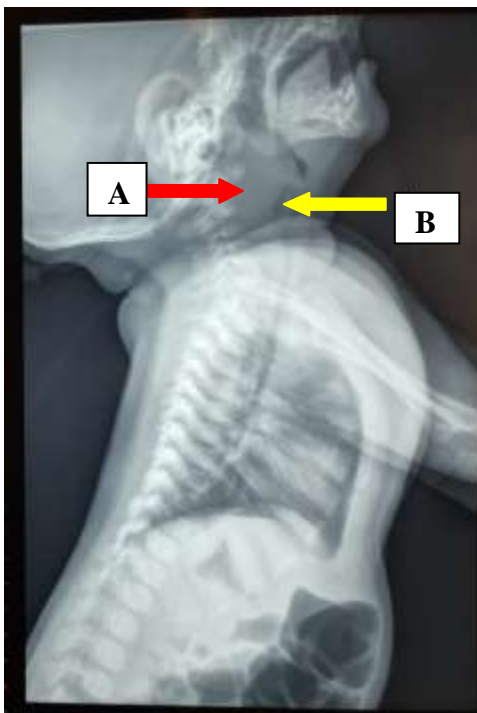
Lateral neck x-ray demonstrating widening of prevertebral space (Arrow A). The airway is indicated by the Arrow B.
